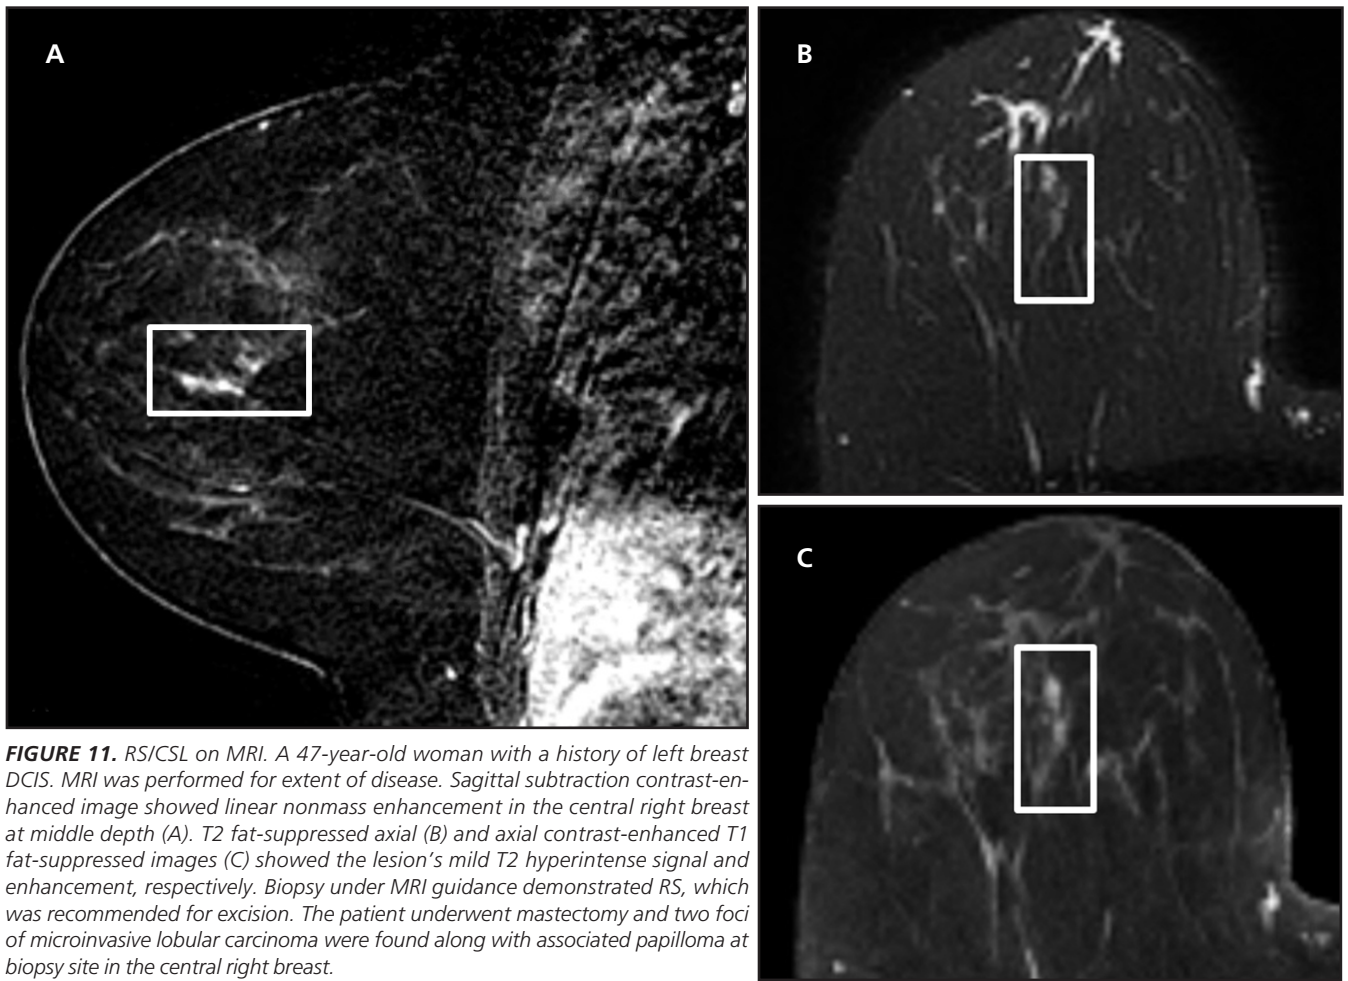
RSICSL on MRI. A 47-year-old woman with a history of left breast DCIS. MRI was performed for extent of disease. Sagittal subtraction contrast-enhanced image showed linear nonmass enhancement in the central right breast at middle depth (A). T2 fat-suppressed axial (B) and axial contrast-enhanced T1 fat-suppressed images (C) showed the lesion's mild T2 hyperintense signal and enhancement, respectively. Biopsy under MRI guidance demonstrated RS, which was recommended for excision. The patient underwent mastectomy and two foci of microinvasive lobular carcinoma were found along with associated papilloma at biopsy site in the central right breast.
